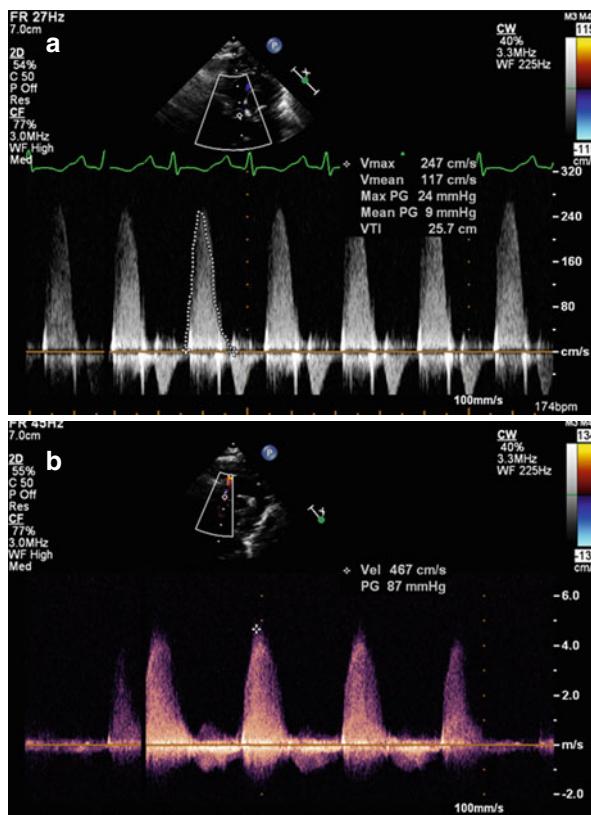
(a) Doppler evaluation of aortic valve from suprasternal angle at presentation showing a peak velocity of 2.47 m/s (peak gradient 24 mmHg, mean gradient 9 mmHg). (b) Post balloon aortic valvotomy continuous wave Doppler evaluation from the suprasternal angle, showing peak velocity of 4.67 m/s. The gradient has “increased” in the setting of improved cardiac output
